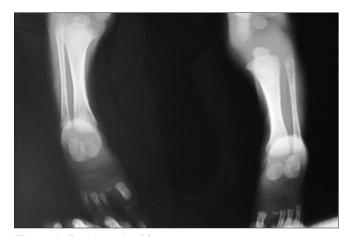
Radiograph of feet
